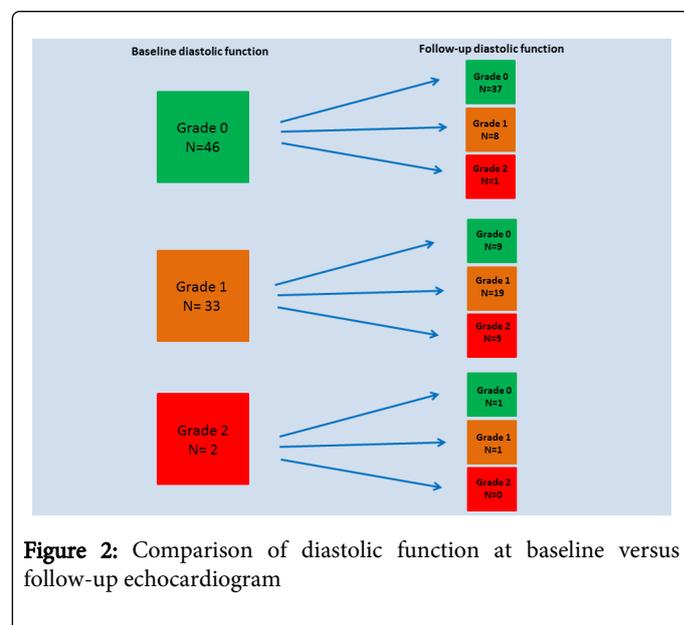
Comparison of diastolic function at baseline versus follow-up echocardiogram
